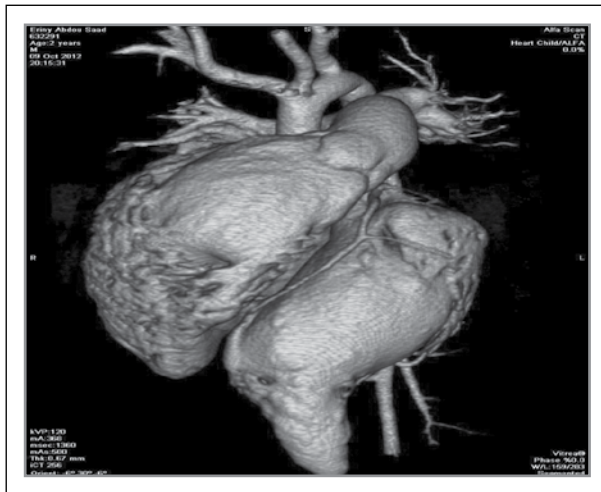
CT Pentology of Cantrell
